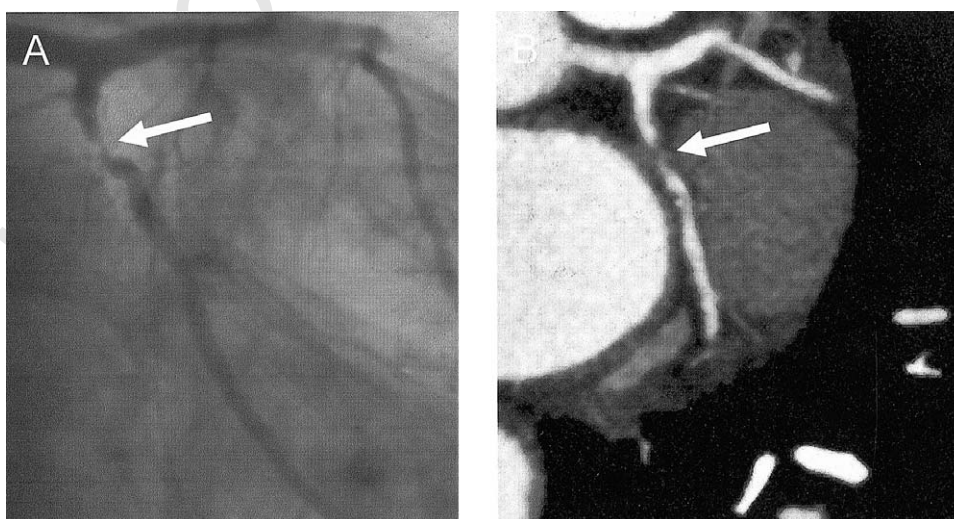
Angiogram (A) and multislice spiral computed tomography (MSCT) (B) of a subocclusive left circumflex artery.
